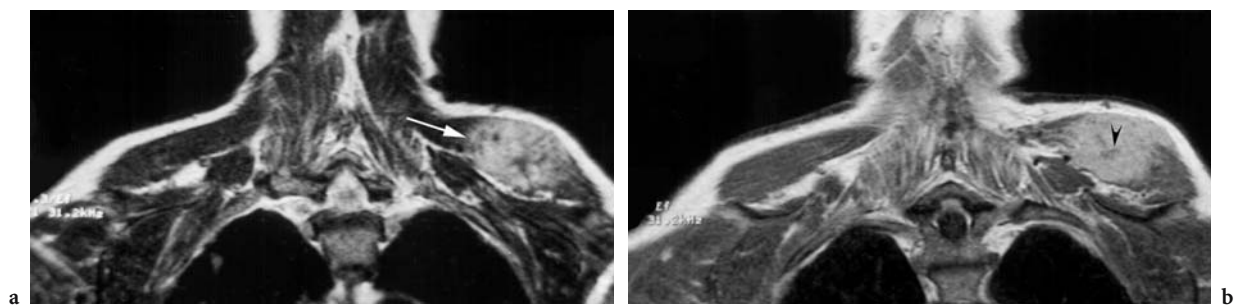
Muscle metastasis in a 63-year-old man with clear cell renal carcinoma 2 years after nephrectomy. a Coronal T2-weighted MR image shows well-defined and slightly heterogeneous hyperintense rounded mass involving the left deltoid muscle (*arrow*). b Coronal contrast-enhanced T1-weighted MR image shows a strong enhancement of the mass with central hypointensity corresponding to tumoral necrosis (*arrowhead*). There is no adjacent involvement of the skin. (Image courtesy of P. SCHATTEMAN)
